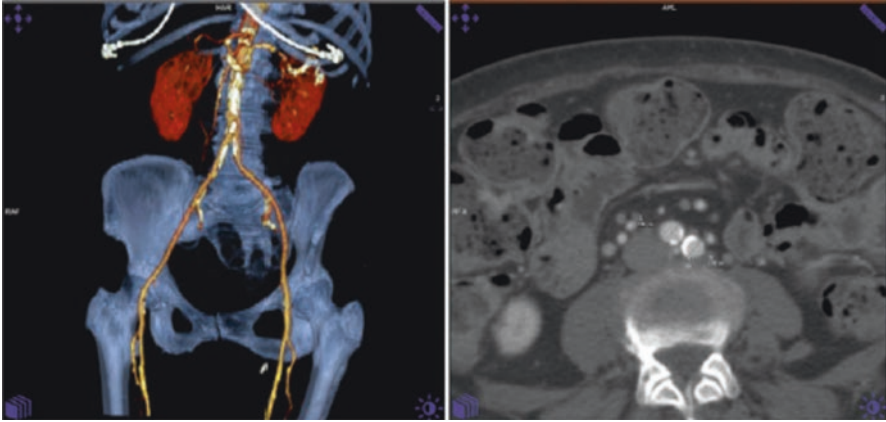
Assessment of vascular access. Computed tomography allows assessment of the iliac anatomy including vessel diameter, calcification, and tortuosity
